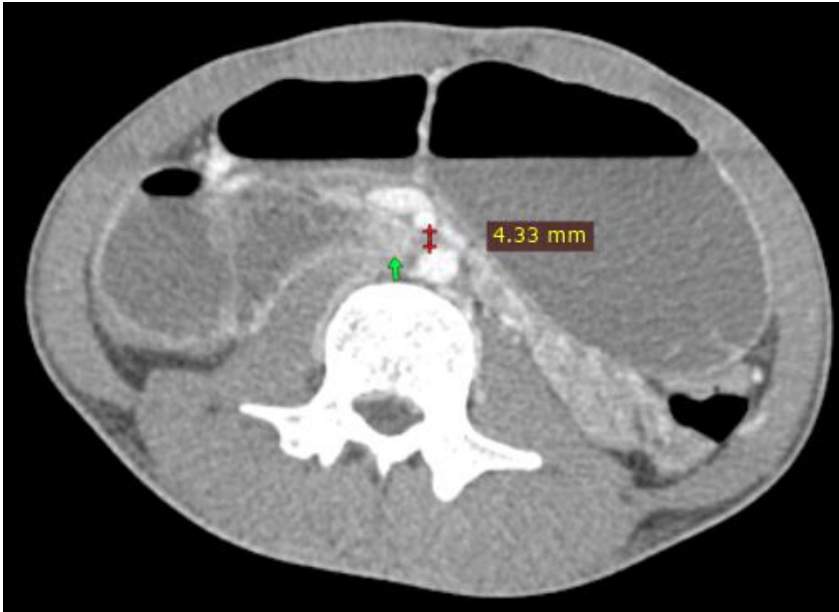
Axial CT image showing abrupt tapering of the third part of the duodenum (green arrow) as it passes between the SMA and the aorta. The aorto-mesenteric distance is reduced, measuring 4mm.
